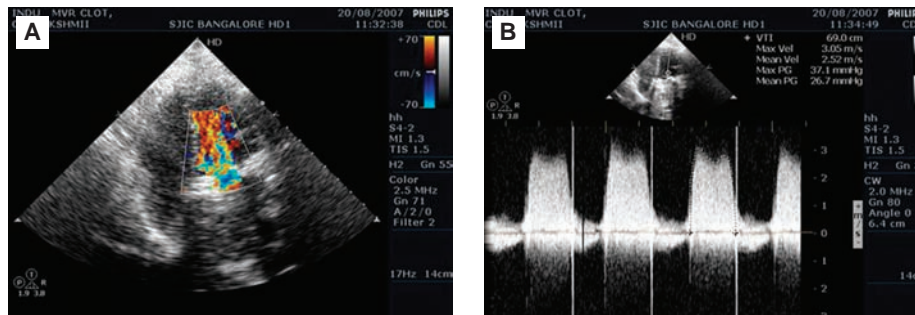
(A) Transthoracic echocardiogram showing turbulence across mitral valve prosthesis with large left atrial thrombus. (B) Continuous wave Doppler recording across prosthetic mitral valve (mean gradient 26.7 mmHg).
